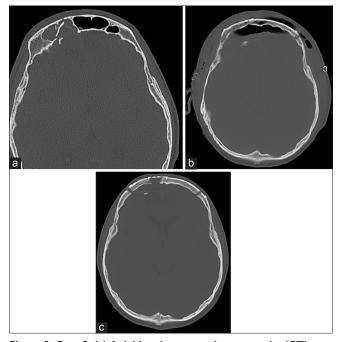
Case 2. (a) Axial head computed tomography (CT) scan with bone windows demonstrating right frontal sinus fracture with near-complete opacification of the frontal sinus; the fracture extended through the anterior and posterior tables and was greater than the full width of the frontal sinus. (b) Postoperative head CT showing successful cranialization of the frontal sinuses and residual pneumocephalus. (c) Follow-up head CT, approximately 1.5 months after surgical intervention, demonstrating good bony healing with significant resolution of the cerebral edema and mass effect
